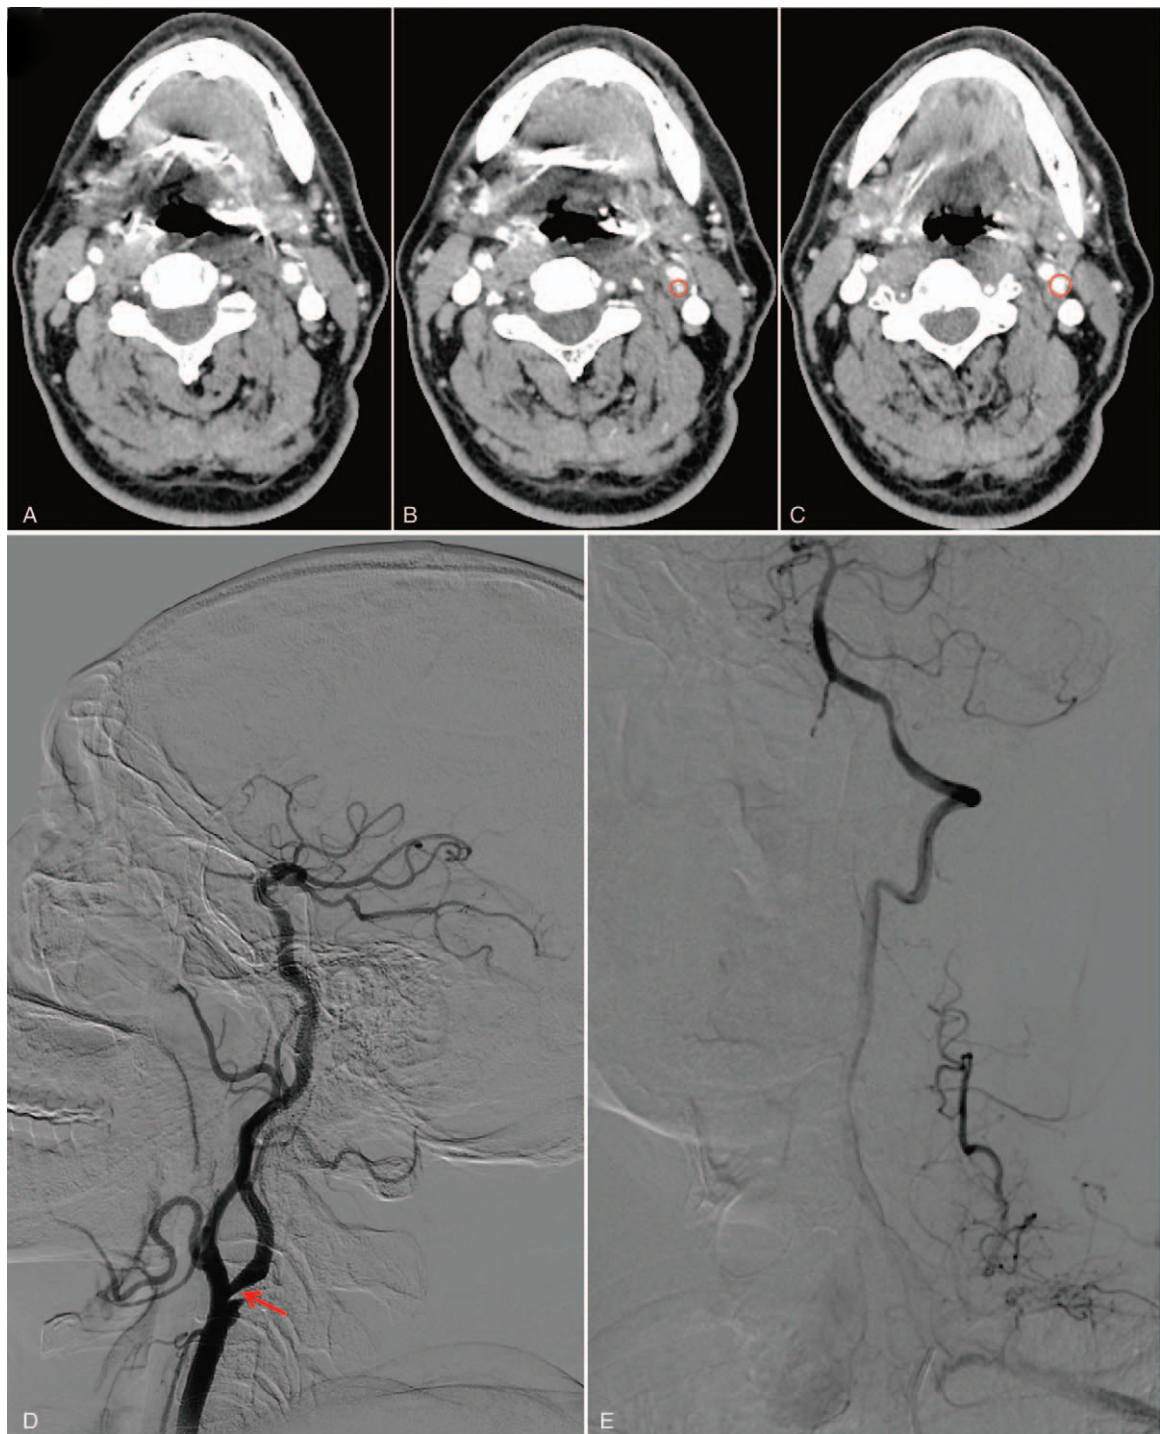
Total cerebral artery imaging. (A–C) Computed tomography angiograph showing cross-sectional image of the left internal carotid artery at cervical level 1. Circled regions indicate severe stenosis. Digital subtraction angiography of the left internal carotid artery (D) showed moderate to severe stenosis, and of the V4 segment of the left vertebral artery (E) showed mild stenosis.
